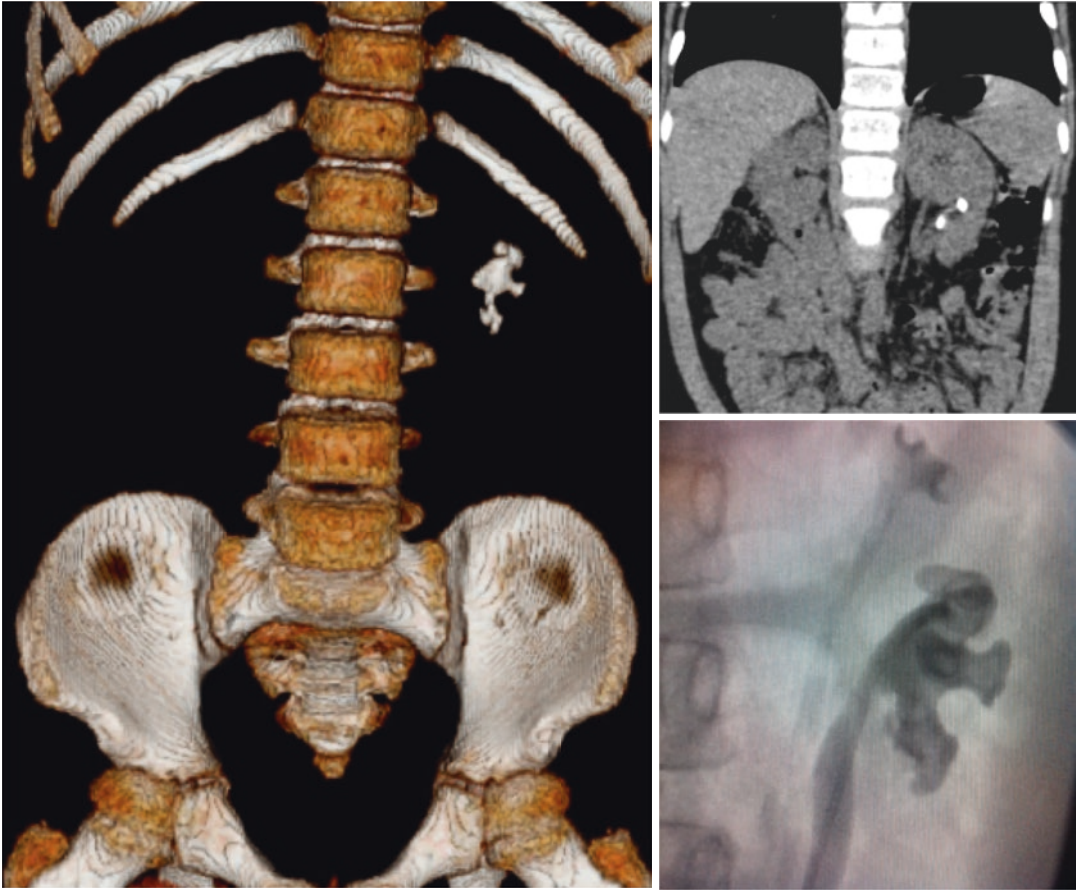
Low-dose 3-D CT. (In this 9-year-old boy initial ultrasonography gave the suspicion of a large stone in the lower part of the left kidney. For treatment planning a low-dose CT [1.7 mSv] was performed, and this examination gave the suspicion of a dual system [upper right], which
